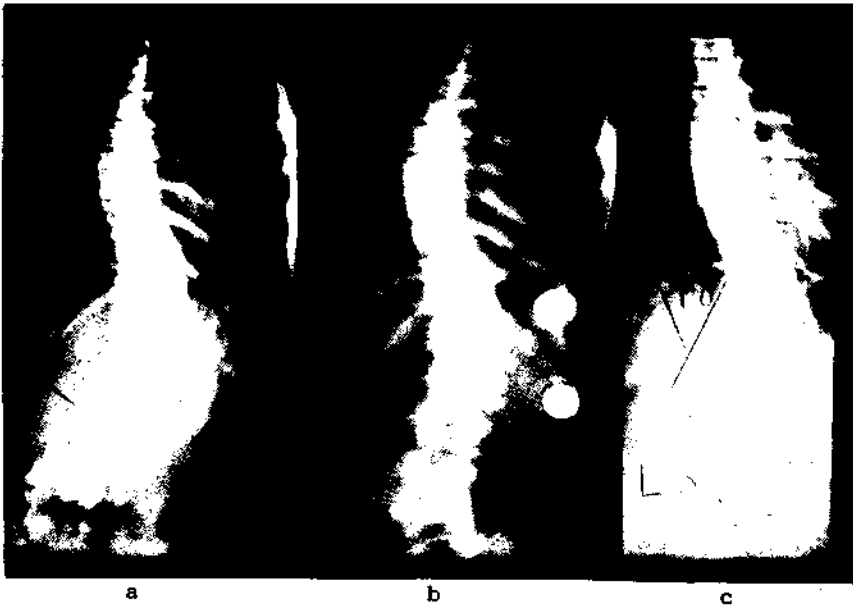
X-ray of the spine a) before FES
